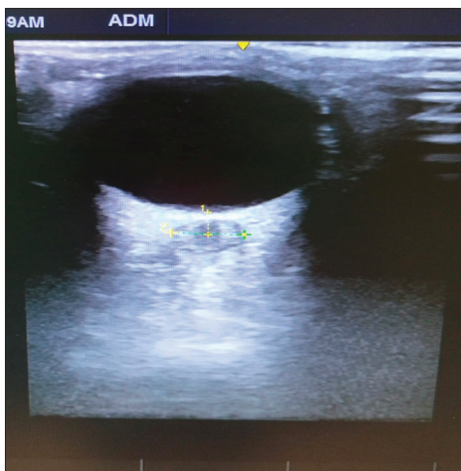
Ultrasonographic measurement of ONSD
